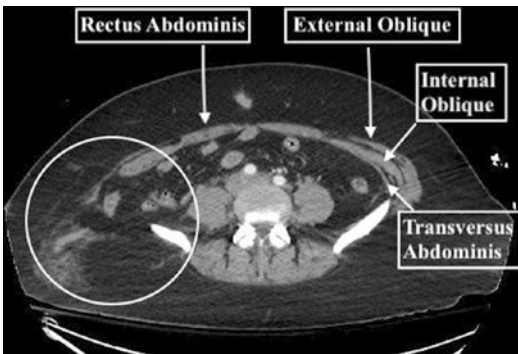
Computed tomography scan of a traumatic flank hernia from a motor vehicle crash. The muscles of the right lateral abdomen have been traumatically avulsed from the attachments to the anterior superior iliac spine ©Photo produced by William W. Hope, MD, 2019
